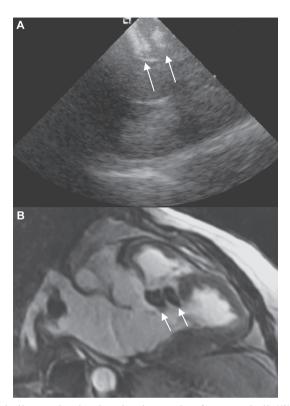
Ablated area visualized by intracardiac echocardiography and corresponding infarct area visualized by MRI long axis (panel B) in a patient who underwent PTSMA of two septal branches.
